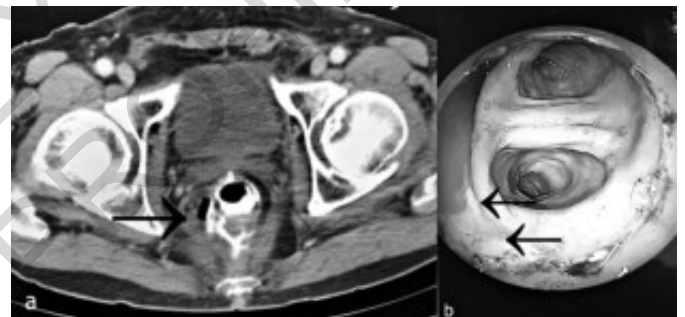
A) CT image; B) endoscopic view of a leak.
